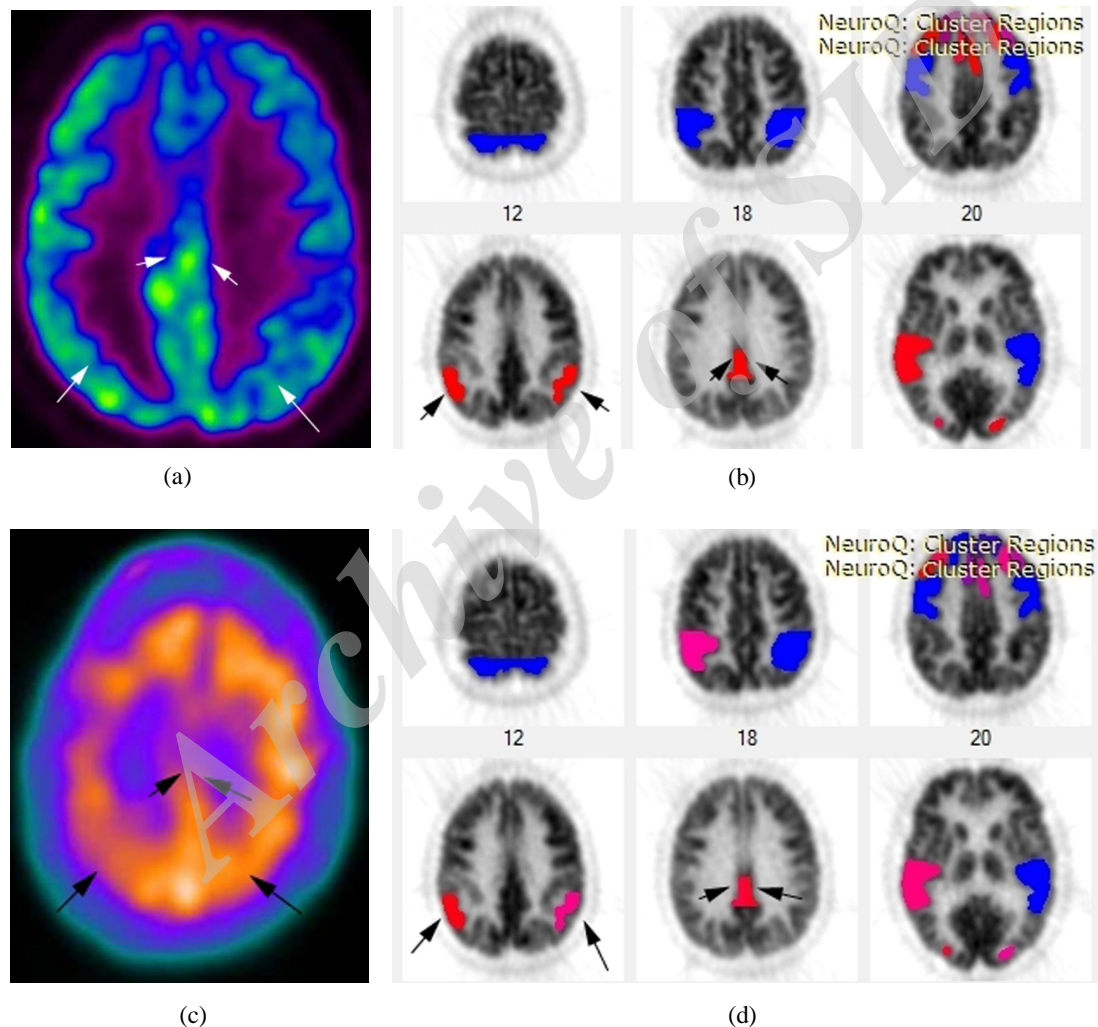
^{18}F -FDG PET axial colored image (a) showing decreased FDG uptake in both posterior parietal (PP) and posterior cingulate nuclei (PCN) Neuro Q analysis colored image (b) showed hypometabolism in the PP regions as well as the PCN (red colored and arrowed) < 3 SD, (c) HMPAO SPECT axial image showing hypoperfused zones in the PP and PCN (d) Neuro Q analysis colored image showing hyperperfused right PP (red colored) < 3 SD, hypoperfused left PP < 2 SD (purple colored) and hypoperfused PCN < 4 SD.
